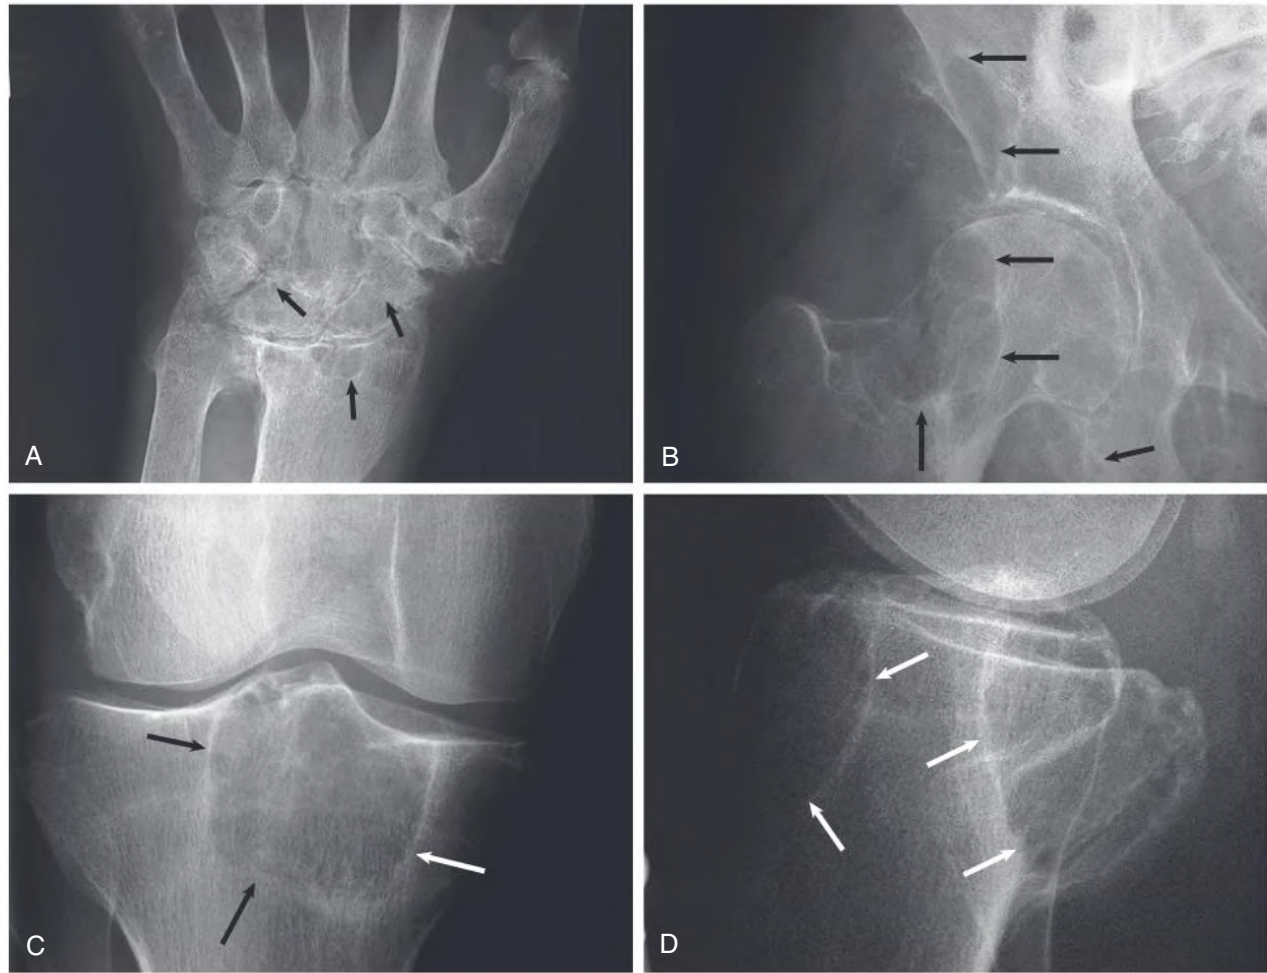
Peripheral Bone Cystic Radiolucencies in β_2 -Microglobulin ($A\beta_2M$) Amyloidosis. Radiographic findings in a long-term hemodialysis patient. (A) Multiple cystic lesions (*arrows*) are present in the hand bones. (B) Large cysts (*arrows*) in the neck of the femur and adjacent pelvic bones. (C–D) Anterior and lateral views of the head of the tibia with two very large, cystic lesions (*arrows*) resulting in posterior bulging of the tibial plateau.
